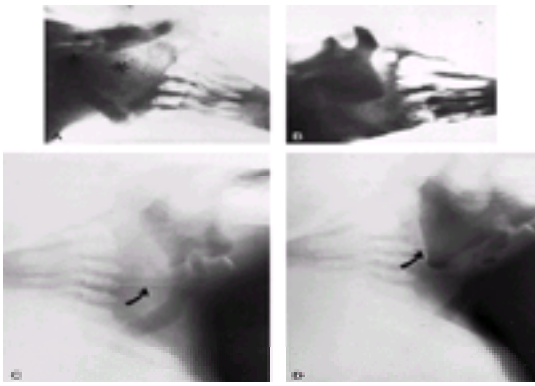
Effects of inspiration and positioning on prevertebral (retropharyngeal) soft tissues. A. Increased prevertebral space with expiration. B. Repeat radiograph in same patient during inspiration reveals normal prevertebral space with no suggestion of cervical spine abnormality. C. Increased soft-tissue space with expiratory phase of respiration. D. Normal soft-tissue space with inspiration in patient C. (A and B reprinted with permission from Harris J, Edeiken-Monroe B. *The Radiology of Acute Cervical Spine Trauma*. 2nd ed. Baltimore: Williams & Wilkins, 1987:6.)
